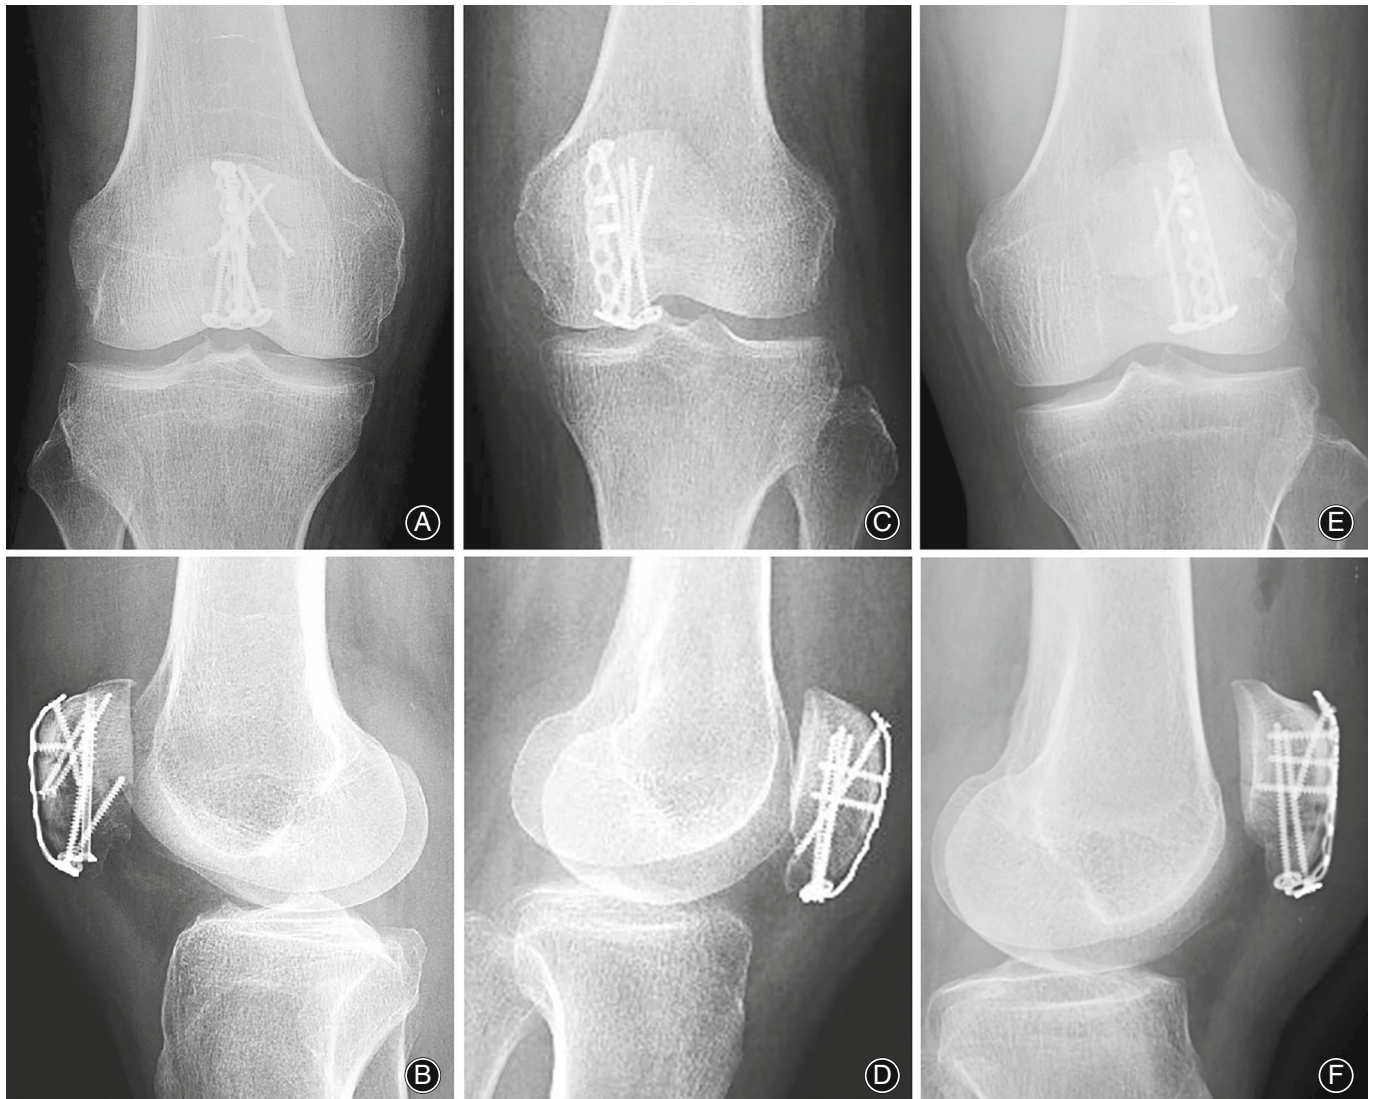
Postoperative radiographs of HPS fixation 2 days post operation. (A) Anteroposterior and (B) lateral images of Patient 1 with AO classification of C1.3 with cannulated screw and lag screw fixation; (C) Anteroposterior and (D) lateral images of Patient 5 with AO classification of C1.3 without supplemental screw fixation; (E) Anteroposterior and (F) lateral images of Patient 25 with AO classification of A1 without supplemental screw fixation.
